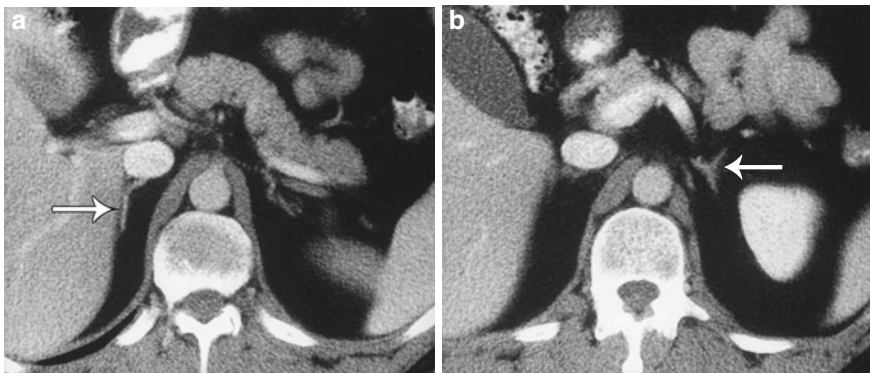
Computed tomography (CT) appearance of normal adrenal glands. (a) The cephalad portion of the right adrenal (*arrow*) is seen. (b) The three limbs of the left adrenal (*arrow*) are shown at this level. (Reprinted with permission from [59])
